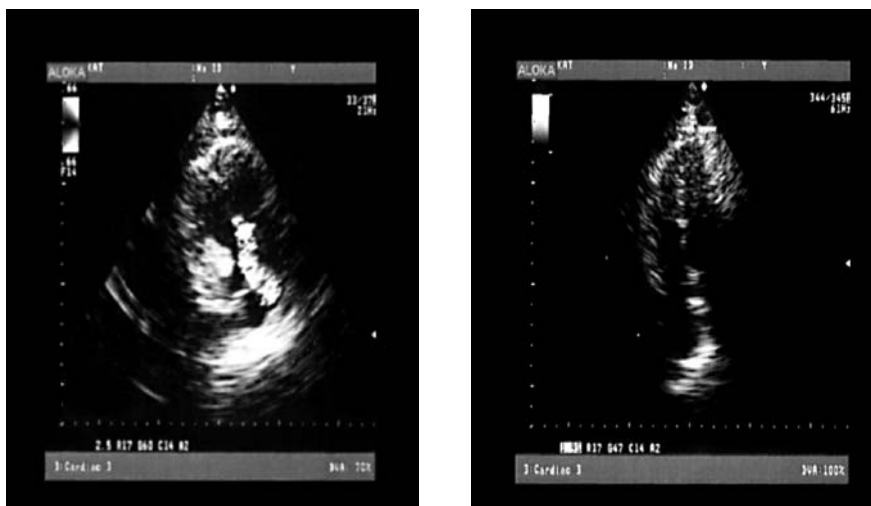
Echocardiogram on admission (left) and after thrombolysis (right). The first image shows hypokinesia of the right ventricular free wall and tricuspid valve regurgitation, which are both improved after therapy.
